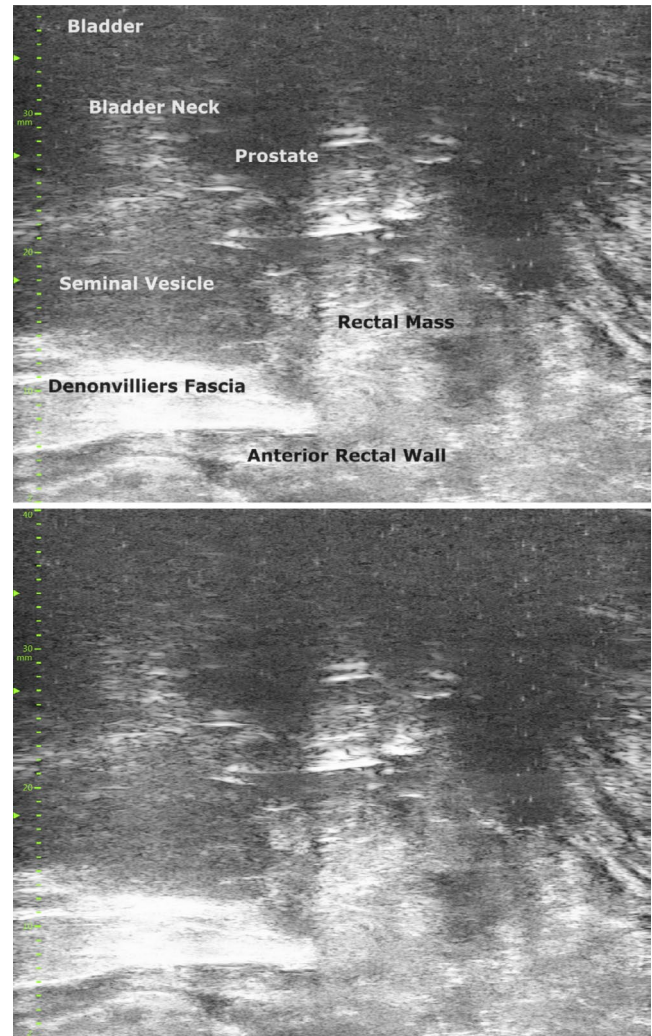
Micro-ultrasound image highlighting the invasion by rectal mass into the prostate and seminal vesicles.
